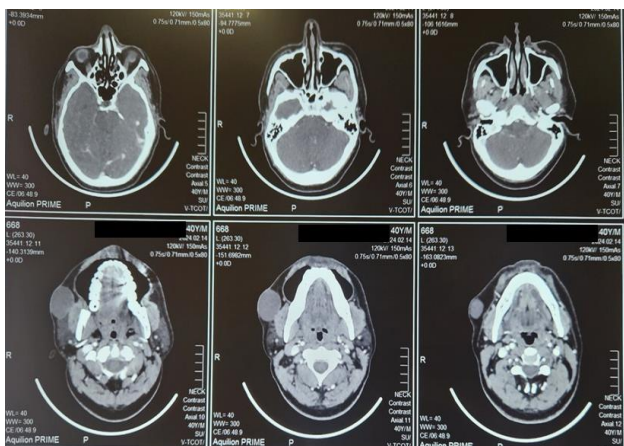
CT scan film showing mass in the subcutaneous plane.
